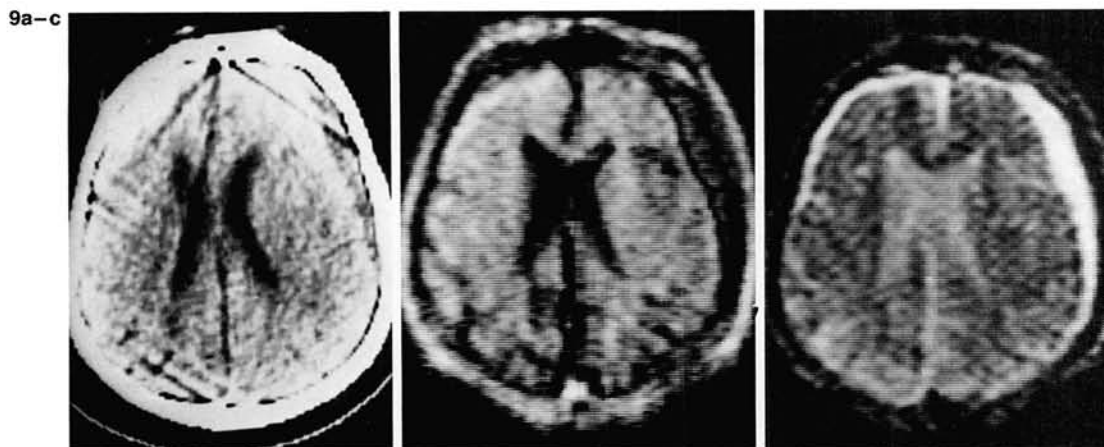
A hygroma is hypodense on CT scan (a) and shows low intensity in the inversion recovery 1,000(250)/70 image (b) due to the relatively long T1 of the lesion. This permits differentiation from subdural hematoma. In the T2 weighted spin echo 2,000/160 image (c) the lesion is visualized as bright due to the long T2.
